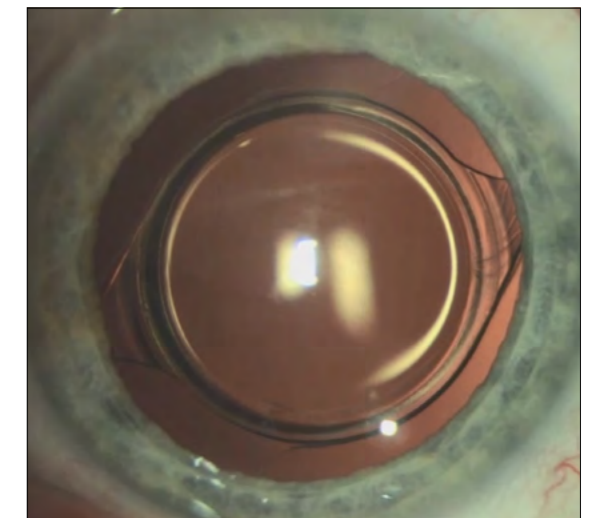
Slit lamp image of the well centered CT LUCIA 621P
